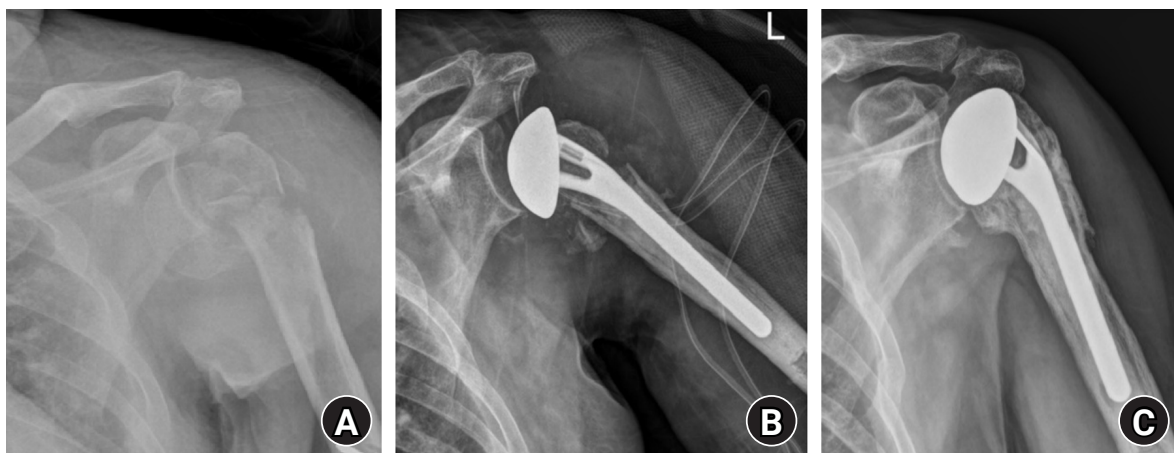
Radiography of the left proximal humerus fracture and dislocation in a 65-year-old male patient. (A) Preoperative anteroposterior radiograph demonstrating a four-part fracture-dislocation. (B) Immediate postoperative anteroposterior radiograph following hemiarthroplasty. (C) Anteroposterior radiograph at the 3-year follow-up demonstrating tuberosity healing.
